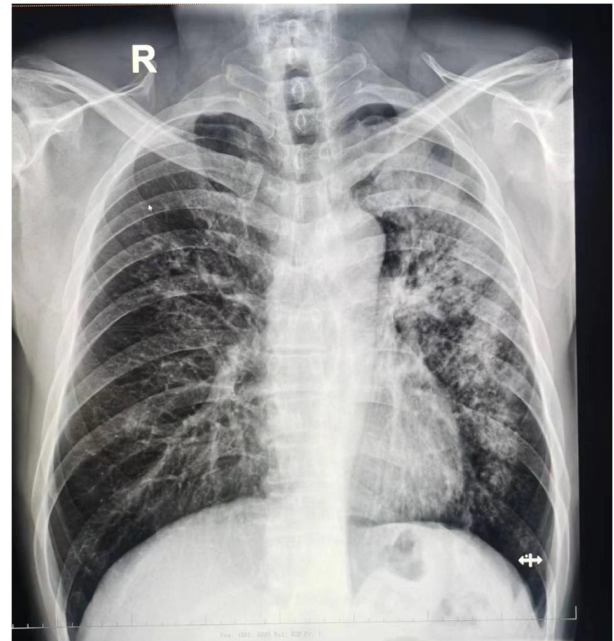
Chest radiograph showing pulmonary lesions, especially in the left lung.
